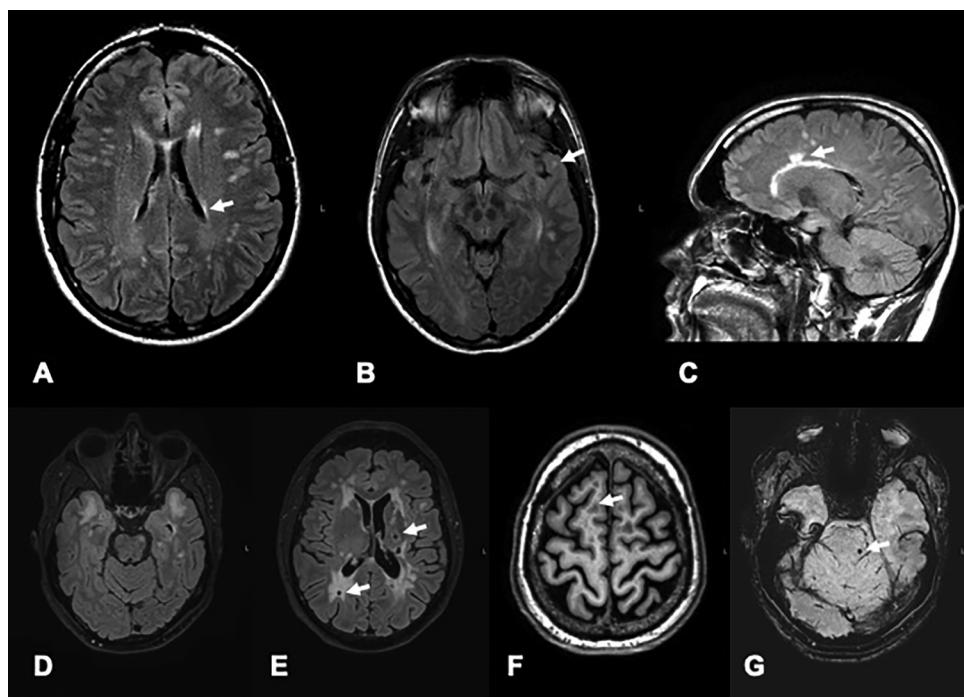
MRI findings in the CADASIL patient 1. A-C. FLAIR sequences upon initial presentation of the patient showing lesions in periventricular (arrow) and unspecific subcortical (A) and juxtacortical (arrow, B) location, as well as in the corpus callosum (arrow, C); D-G. Latest follow-up MRI sequences depicting now CADASIL-typical findings with marked FLAIR-hyperintense, confluent lesions increased in both temporal poles (D), lacunar post-ischemic defects in the white matter and the basal ganglia (arrows, E), spared cortical ribbon (arrow) in subcortical lesions on T1w sequence (F), and exemplary, unspecific microbleed (arrow) in SWI sequence (G). L = left, P = posterior.
